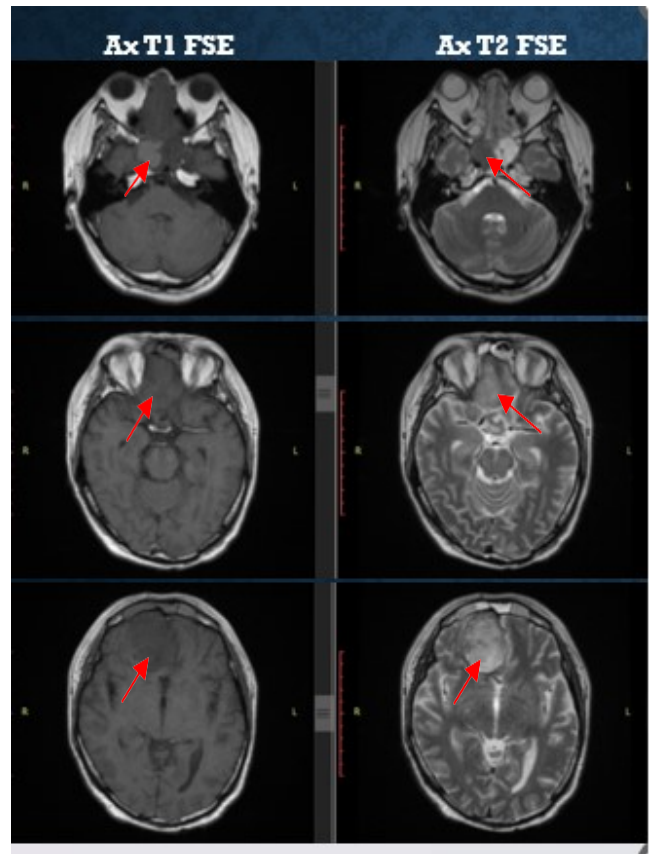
Preoperative axial brain MRI sequence T1, T2, T1 Contrast, T2 Flair
